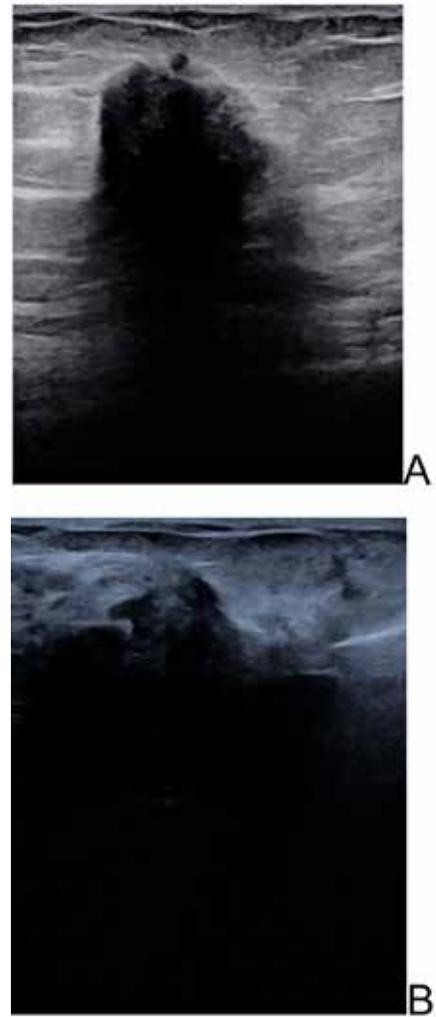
Ultrasonography. Bilateral breast carcinoma. A. Irregularly shaped nodule, located in the UIQ of the right breast, spiculated, indistinct and angular margins, hypoechoic, non-parallel orientation and posterior acoustic shadow. B. Tumor located in the UOQ of the left breast with an irregular shape, spiculated, indistinct and angular margins, hypoechoic, non-parallel orientation and posterior acoustic shadow.
